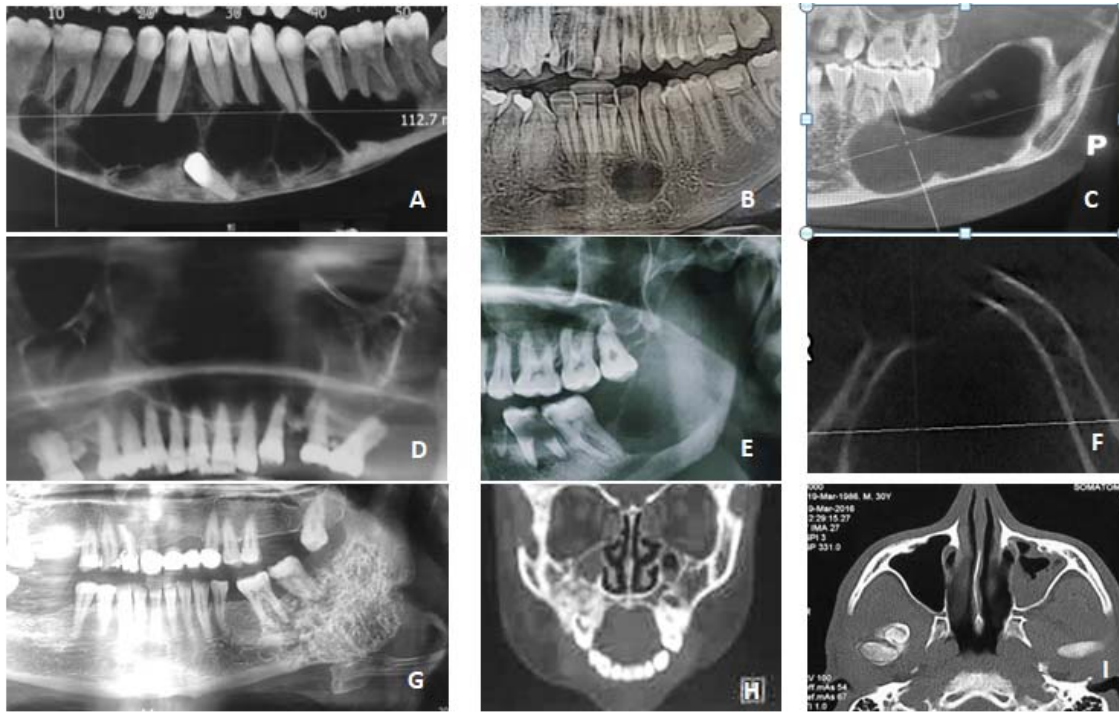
Radiographical features of different jaw lesions. (A) panoramic view of CBCT, dentigerous cyst; a large, well-defined radiolucency associated with an impacted tooth. (B) OPG, traumatic bone cyst; a small, well-defined radiolucent lesion. (C) CBCT, keratocyst; a well-defined radiolucent lesion. (D) OPG, radicular cyst; a large well-defined radiolucent lesion. (E) OPG, osteosarcoma, a large ill-defined radiolucent lesion in the angle of mandible extended to involve the ramus. (F) CBCT, giant cell lesion; a large ill-defined radiolucent lesion. (G) OPG, the mixed radiolucent-radiopaque lesion (Pindborg tumor). (H) Coronal CT mixed radiolucent-radiopaque lesion (fibrous dysplasia). (I) Axial CT, osteoma, radiopaque lesion on the condyle.
